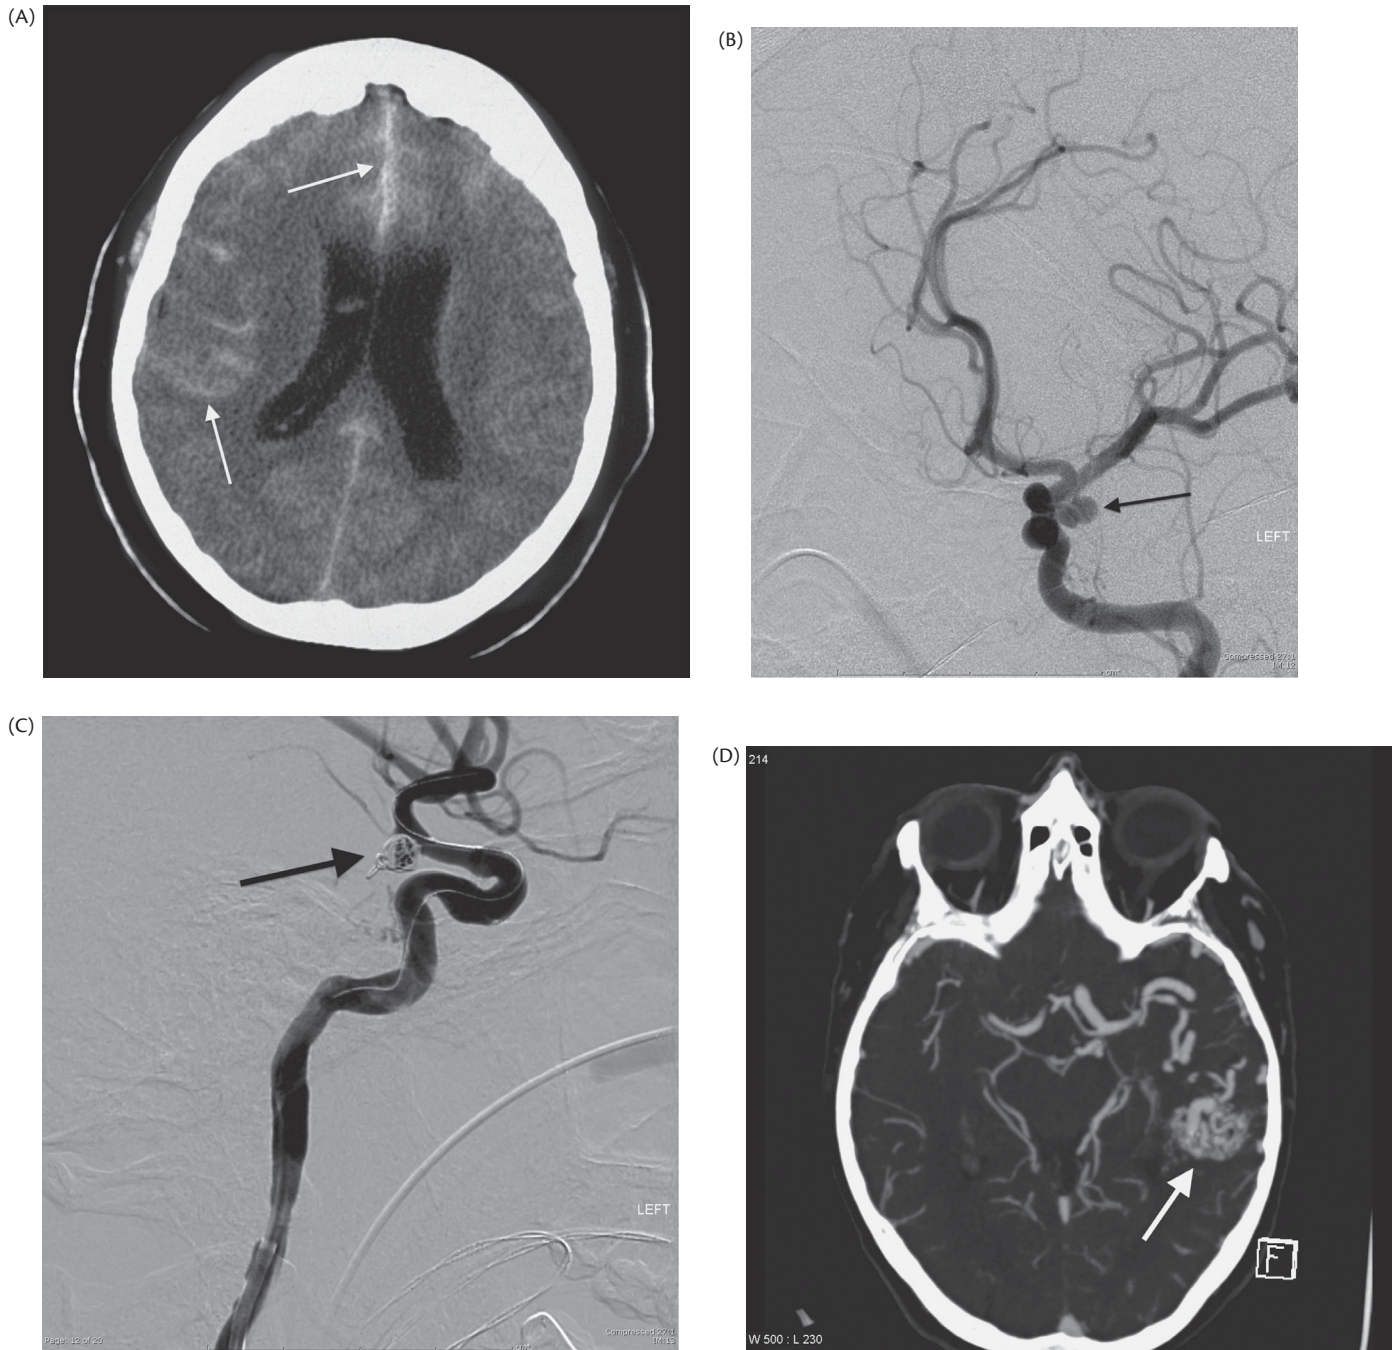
(A) Axial CT scan brain showing subarachnoid haemorrhage with hyperdense blood in the interhemispheric region and cortical sulci (arrows). (B) Oblique projection of a left internal carotid angiogram showing a posterior communicating artery aneurysm (arrow). (C) Left internal carotid angiogram during endovascular coiling of the posterior communicating artery aneurysm in (B) showing the loosely packed coil mass (arrow). (D) Axial CT angiogram showing a left temporal arteriovenous malformation.
